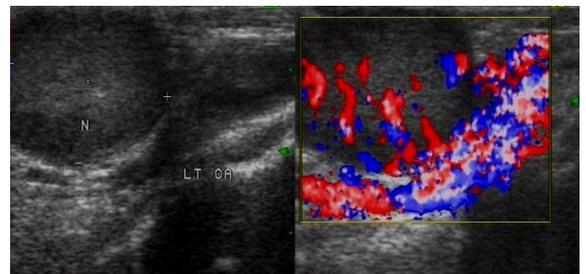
Nodal Metastases: Ultrasound showing nodal masses with predominantly peripheral vascularity.
